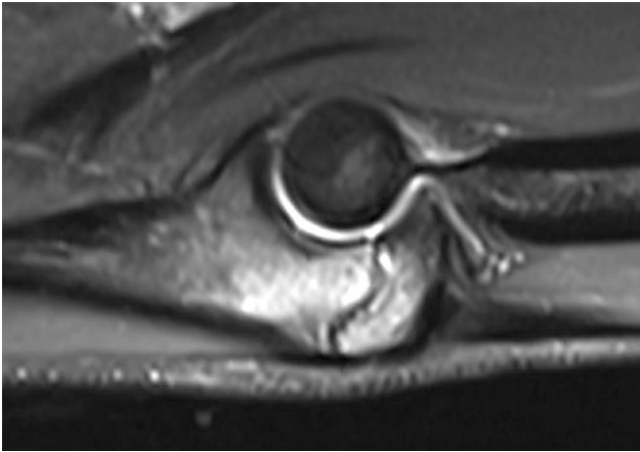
Stress fracture. A 17-year-old male with 6-month history of posterior elbow pain exacerbated by weight lifting. Sagittal STIR image demonstrates a non-displaced fracture and prominent marrow edema in the olecranon. The olecranon physis was found to be fused in the opposite elbow on radiographs
